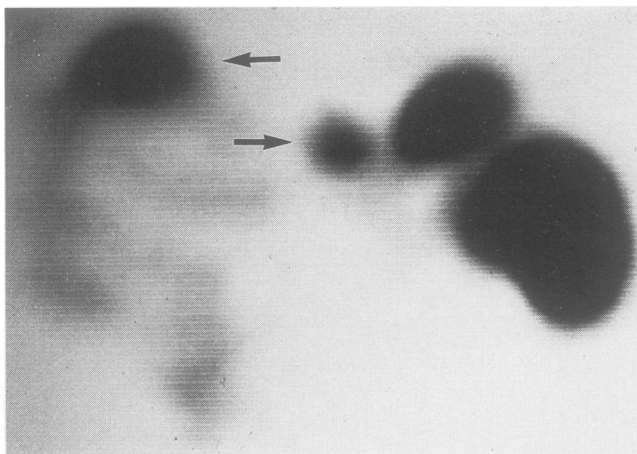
Hepatic artery perfusion scintigraphy in the patient from Figure 2 accurately demonstrates uptake in the large dome lesion on the right (arrow) and an obvious discrete lesion in the left lateral segment (arrow) near the splenic and gastric uptake of the macroaggregated albumin. The left lateral segment lesion was seen as a cyst in Figure 2.
